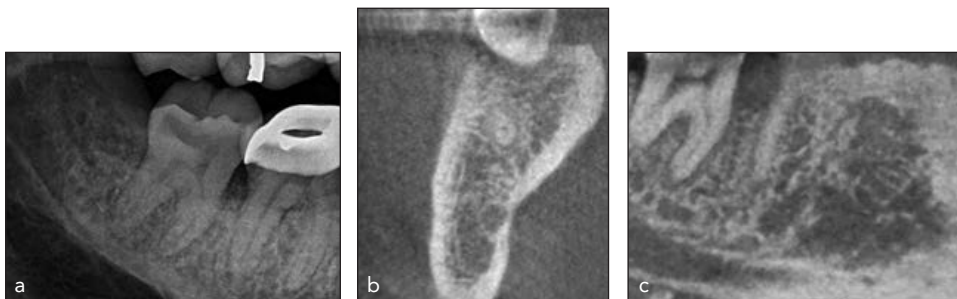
Radiographic depictions of inferior alveolar nerve canal adjacent to mandibular molars: (a) periapical radiograph, (b) coronal section of CBCT, and (c) sagittal section of CBCT.
